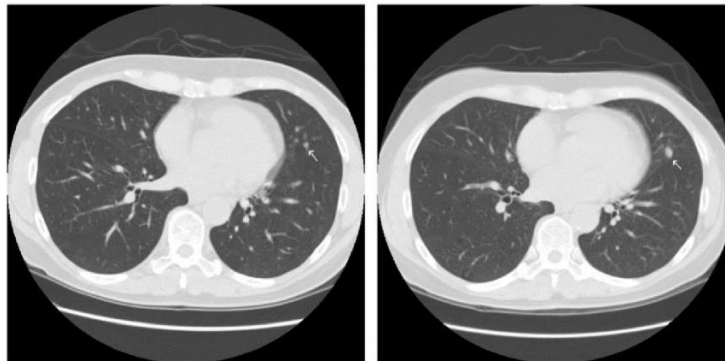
CT scan image of the lungs^[15].
